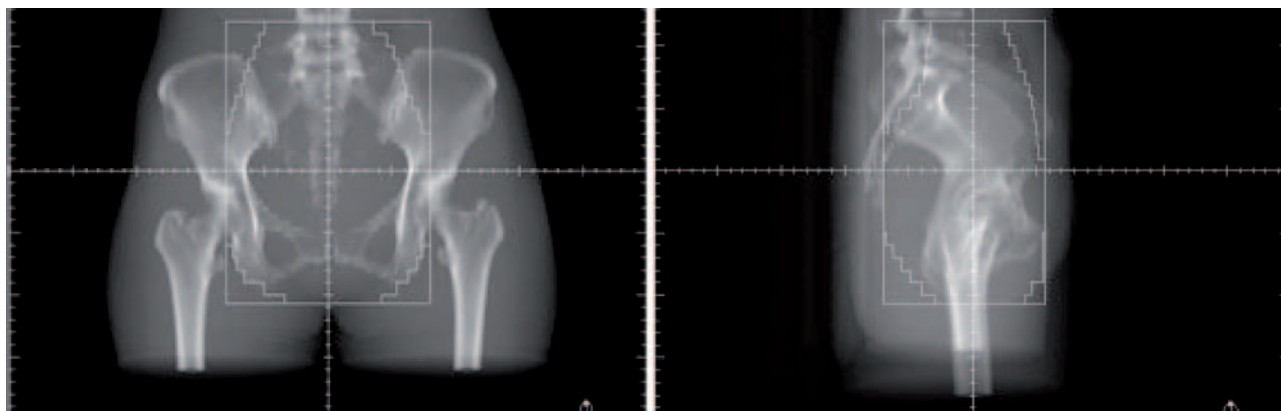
Digitally reconstructed radiograph of the anterior and lateral treatment fields for pelvic radiotherapy
